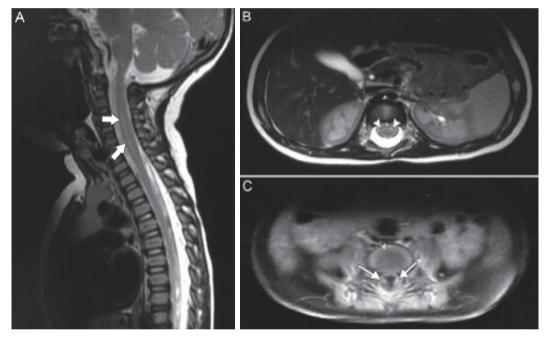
MRI of spine showing: A) Saggital, T2 high signal intensity in the cervical spinal cord at the level of C2 to C5. B) Axial, enhancement of the lower cervical spinal cord segment. C) Axial, enhancement of the dorsal spinal cord at the level of D5 through the conus medullaris associated with thickened enhancing filum roots
